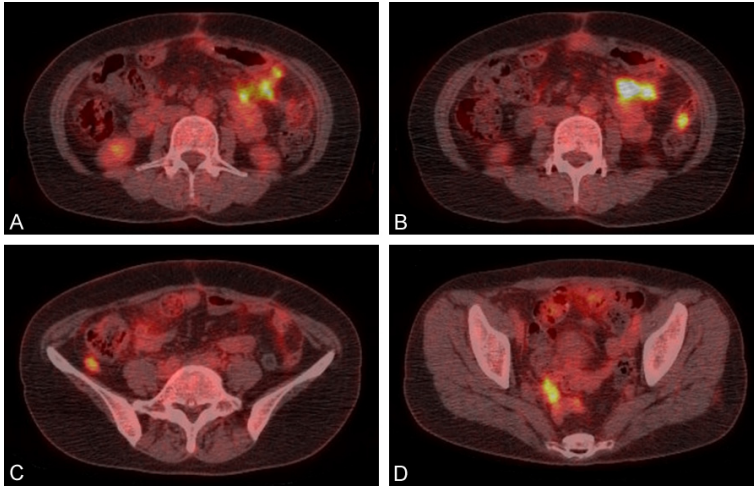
Positron emission tomography-computed tomography findings (A-D) showed multiple hypermetabolic nodular lesions in the left upper quadrant abdominal mesentery, wall of the descending colon, right paracolic gutter, right pelvic cavity, and cul de sac ($SUV_{max} = 8.4$), suggesting peritoneal seeding.
